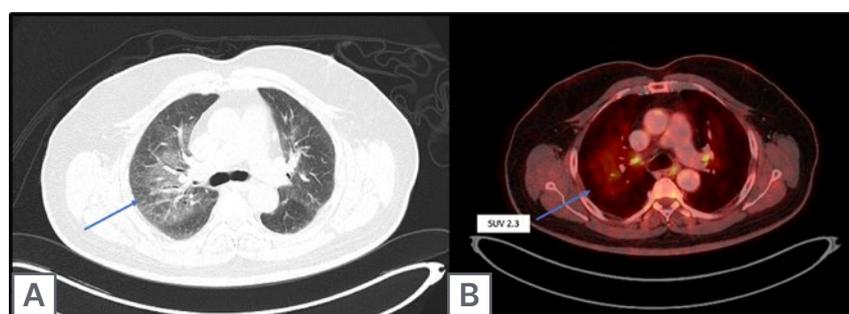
A 47-year-old female patient, with Hodgkin's lymphoma, was referred for PET/CT evaluation.
